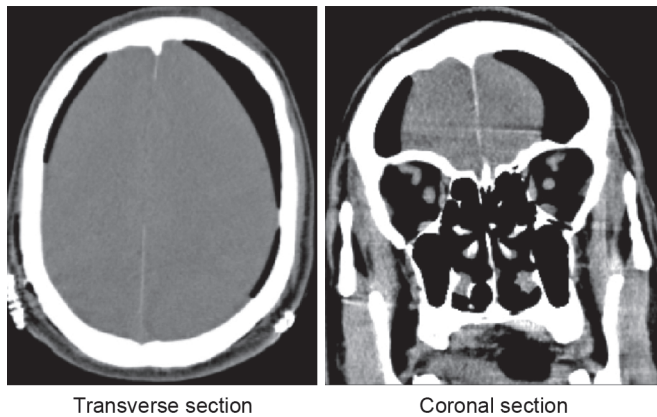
Transverse and coronal sections of CT brain showing a large bilateral frontal tension pneumocephalus known as the Mount Fuji sign, following burr-hole evacuation of SDH
